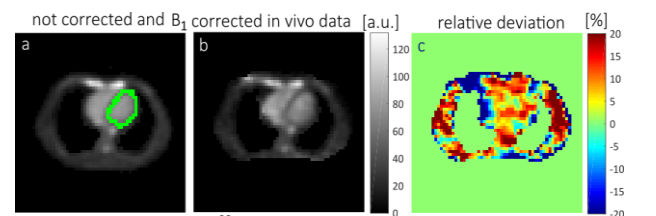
(a) Cardiac ^{23}Na MR image at $B_0=7\text{T}$ with binary mask based on ^1H . The acquisition time was 16min with 44000 projections. (b) Cardiac in vivo image corrected with B_1^- . (c) Relative deviation map of corrected (b) and not corrected (a) image
